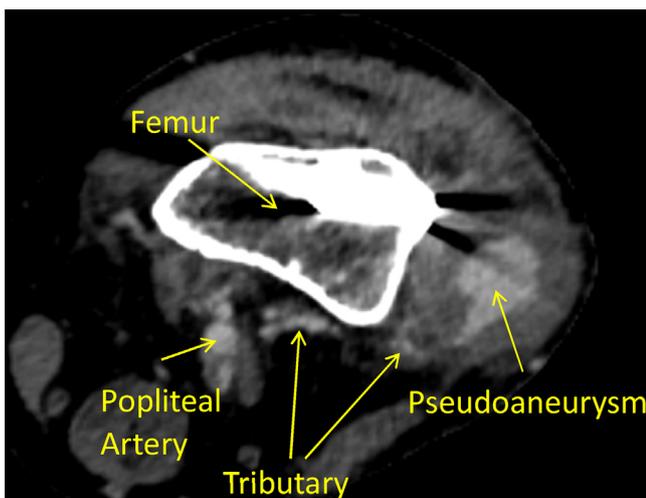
Computed Tomography Angiogram (CTA) of the lower extremity depicting the pseudoaneurysm arising from the popliteal artery.
